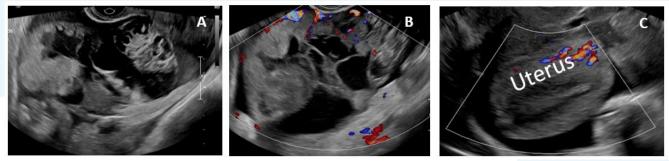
Ultrasound right ovary and uterus. A. Sagittal gray scale ultrasound right ovary which demonstrates a multilocular cyst with solid components. B. Sagittal colour Doppler ultrasound right ovary demonstrates minimal internal vascularity. C. Ascites surrounds the uterus extending above the fundus.
